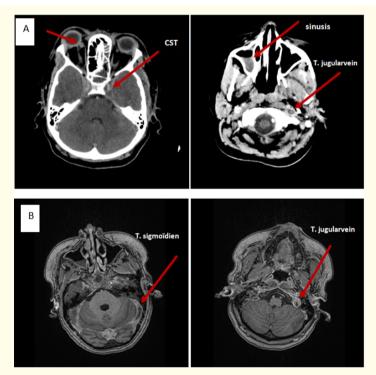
CT scan (A) and MRI T-weighted (B): Thrombosis of both cavernous sinuses and the right ophthalmic vein extending to sigmoid and transverse sinuses, and both internal jugular veins.
